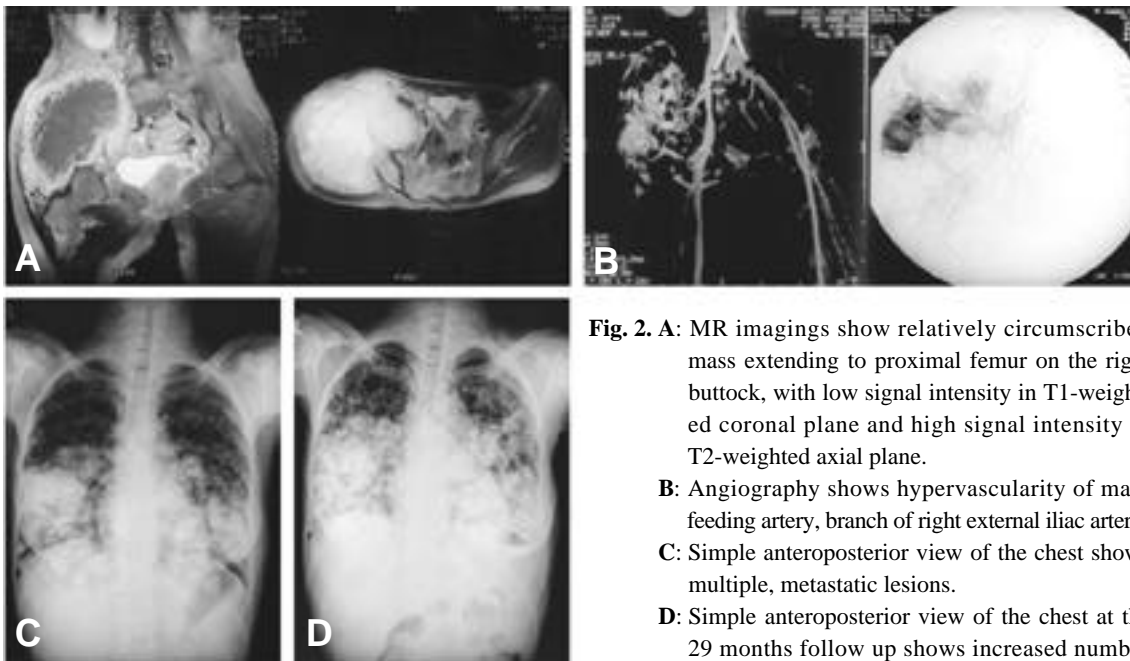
A : MR imagings show relatively circumscribed mass extending to proximal femur on the right buttock, with low signal intensity in T1-weighted coronal plane and high signal intensity in T2-weighted axial plane.
